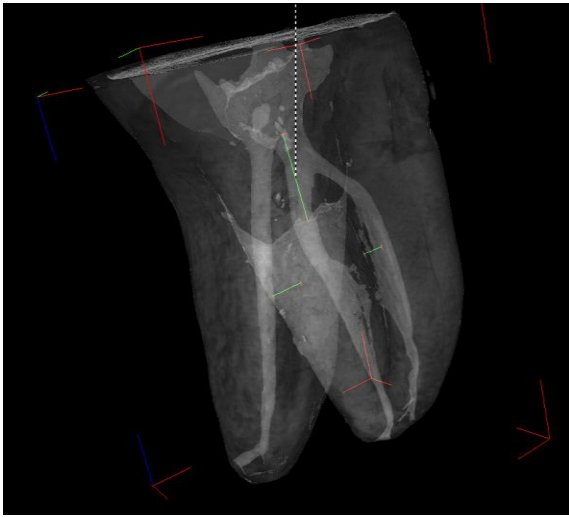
Micro CT image of a second mandibular molar
